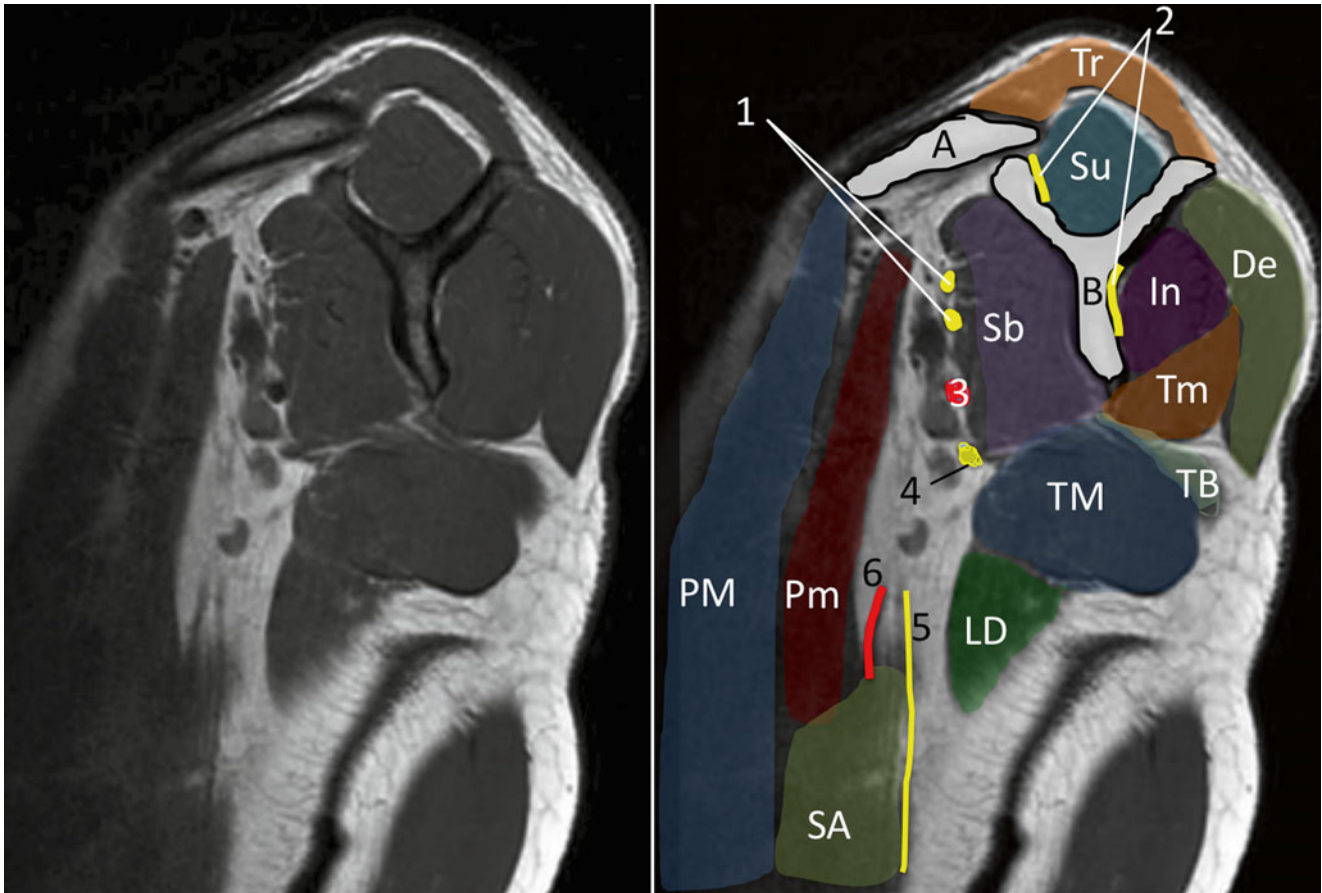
Sagittal MRI image scapular muscles. *A* clavicle, *B* scapula, *De* deltoid muscle, *In* infraspinatus muscle, *LD* latissimus dorsi muscle, *PM* pectoralis major muscle, *Pm* pectoralis minor muscle, *Sb* subscapularis muscle, *Su* suprascapular muscle, *TM* teres major muscle, *Tm* teres
